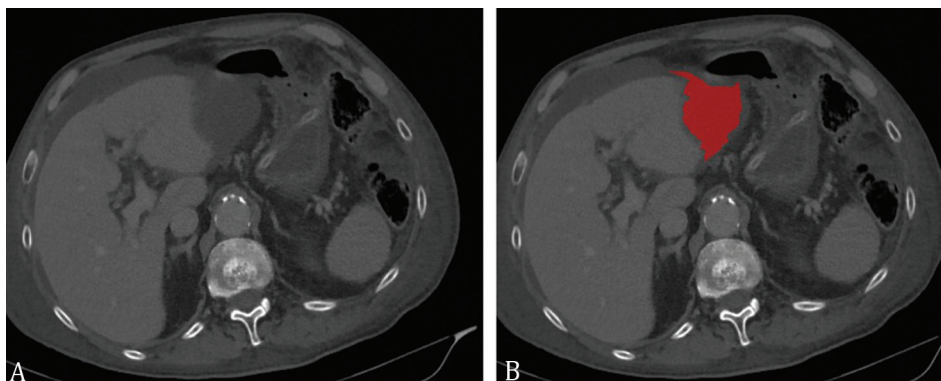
(A) Axial CT non-enhanced phase image of a 61-year-old patient with non-infected fluid collection following surgery. (B) The slice with the region of interest (red area) used for texture analysis.
